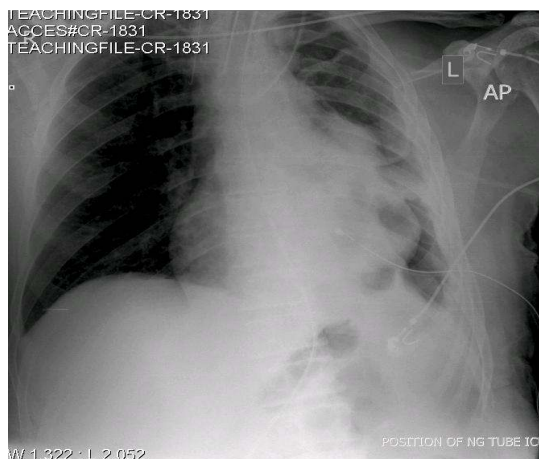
4 (CR-1831). This chest radiograph shows an unusual complication where the guide wire has been left accidentally in situ on the right side. (Note the presence of the J-shaped guide wire on the right side of the neck). This can result in serious complications if the guide wire migrates distally.
